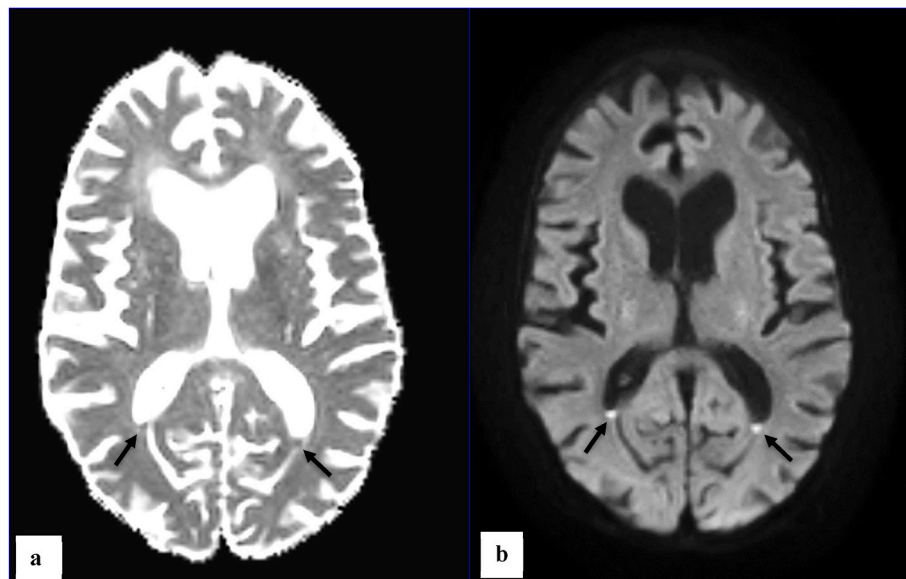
(a+b): MRI without contrast showing signs of restricted diffusion (black arrows) in both ventricles.
